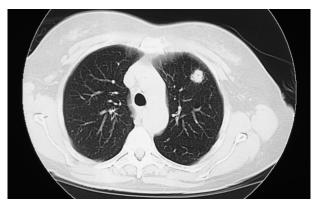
Computed tomography scan of the chest showing a peripheral heterogenous mass in the left lung.
